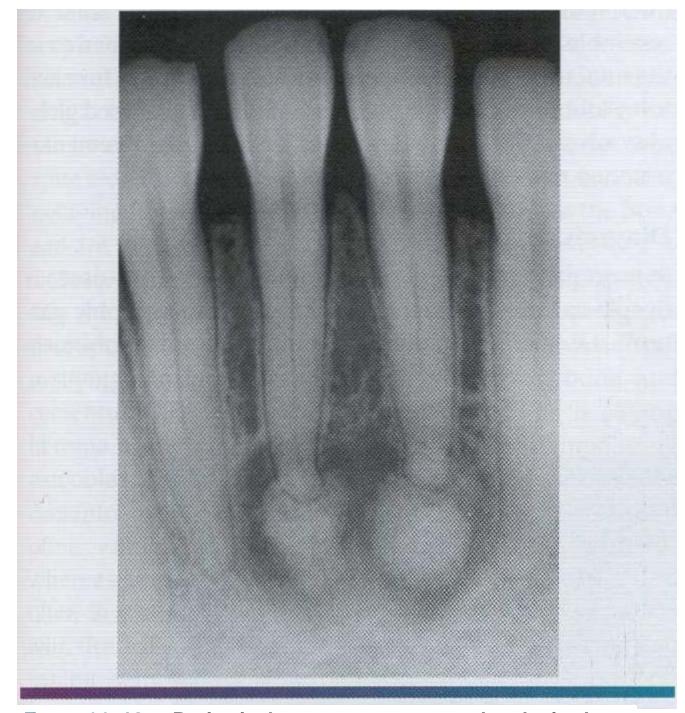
• Periapical cemento-osseous dysplasia. Later stage lesions exhibiting significant mineralization.
